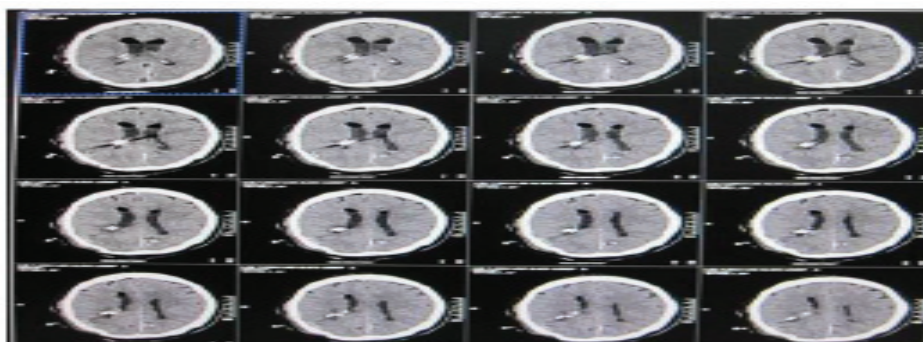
Postoperative-axial Head CT-scan Showing an Intraventricular External Drainage Device and the Clip for AChA Aneurysm
